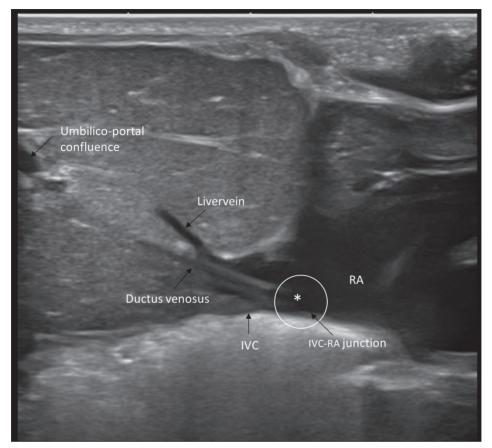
Ultrasound image of an umbilical venous catheter with correct position of the tip (asterisk). The tip of the catheter is localized at the junction of the inferior vena cava (IVC) and right atrium (RA).
